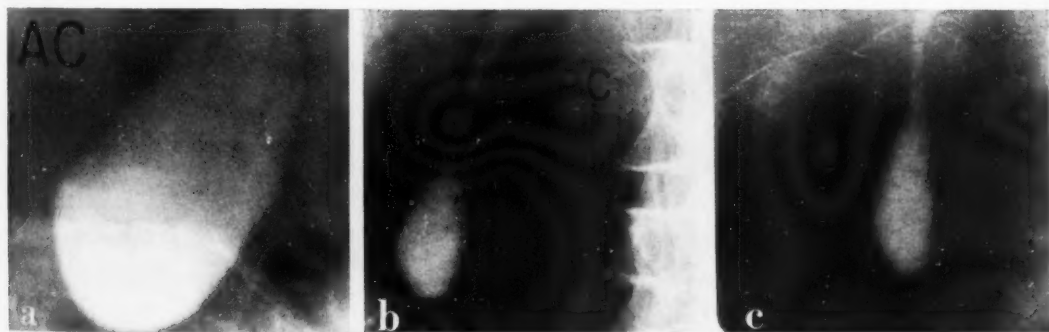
Roentgenograms (a) before and (b and c) 10 minutes after a fat meal, all exposures being made in the erect position with the pressure "spot film" device. *Note—*
